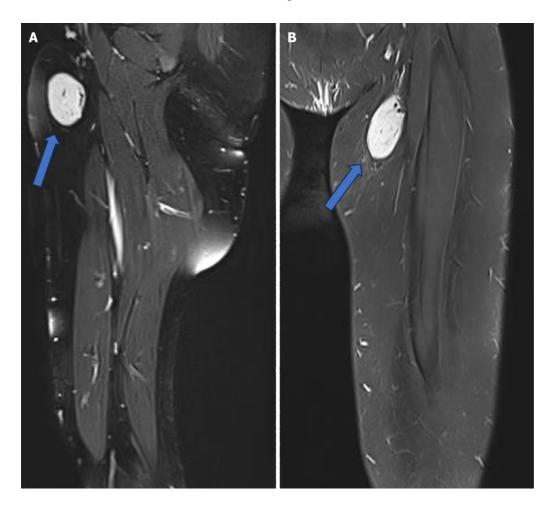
Magnetic resonance imaging showed a well-circumscribed and demarcated cystic lesion projected in the left inguinal region with eccentrically positioned signal void vascular, likely lymphoid in nature (arrow). A: Sagittal view. B: Coronal view.
